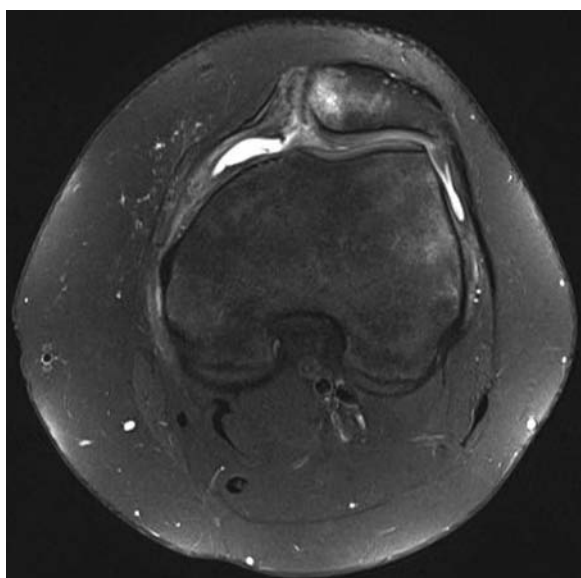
Transverse gradient-echo magnetic resonance image of the knee 3 days after acute patellar dislocation shows partial injury to the femoral origin of the medial patellofemoral ligament (MPFL). There is extensive surrounding edema and complete tear of the patellar insertion of the MPFL.
